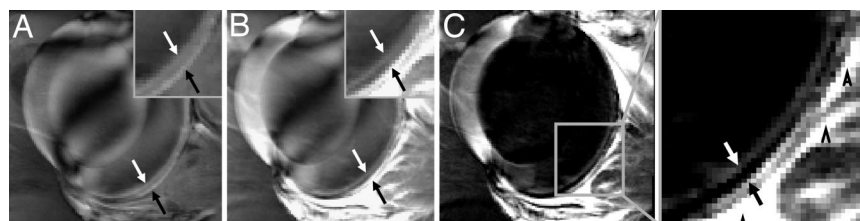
Contrast-enhanced MRI delineating two vascular layers bounding the retina. (A and B) Contrast-enhanced images at $60 \times 60 \mu\text{m}$ before (A) and after (B) Gd-DTPA administration. (C) The subtracted image. The two arrows in the expanded views indicate the inner and outer bands of the retina corresponding to the two vascular layers bounding the retina. The dark lines across the lens arose from magnetic and radiofrequency heterogeneity. Three arrowheads indicate signal enhancement of extraocular tissues supplied by Gd-DTPA permeable vessels.
